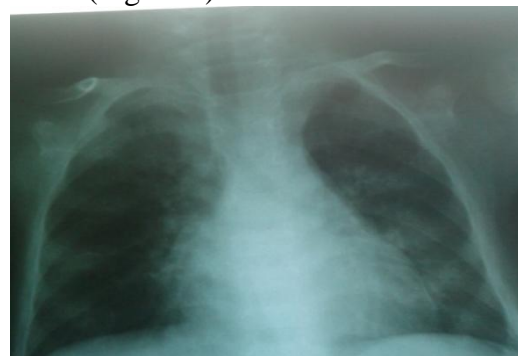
Chest x-ray of rachitic patient
